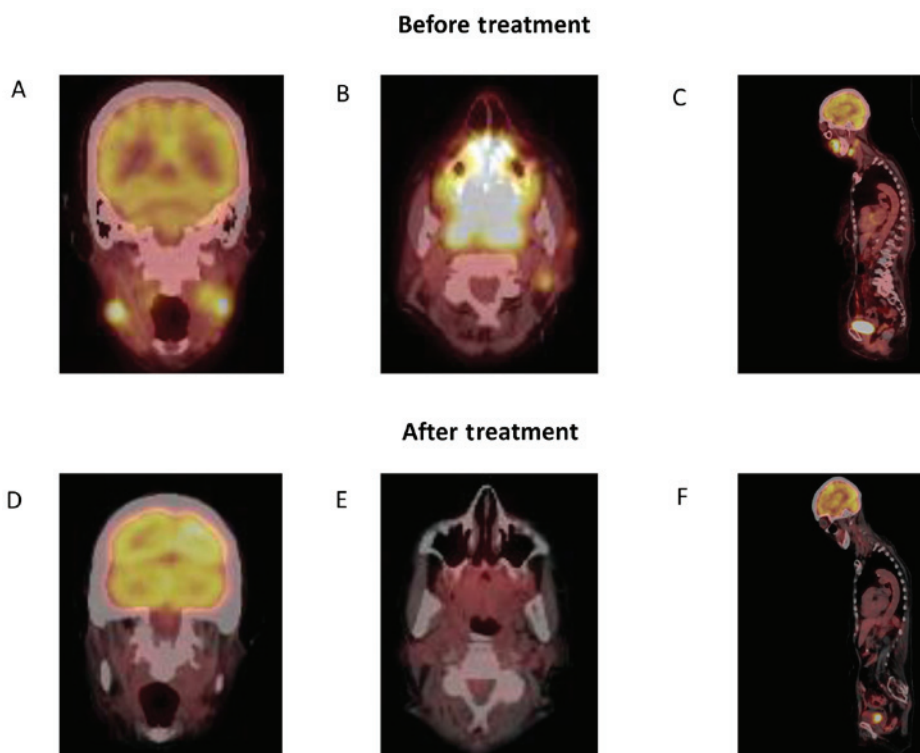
(A-C) Positron emission tomography-computed tomography examination revealed a left submandibular mass measuring 2.6x2.0 cm, with an SUV of 14.4, and a large nasopharyngeal mass, sized 4.5x3.5 cm, with an SUV of 16.3. (D-F) Marked improvement in radiographic response of the retropharyngeal mass. SUV, standardized uptake value.
